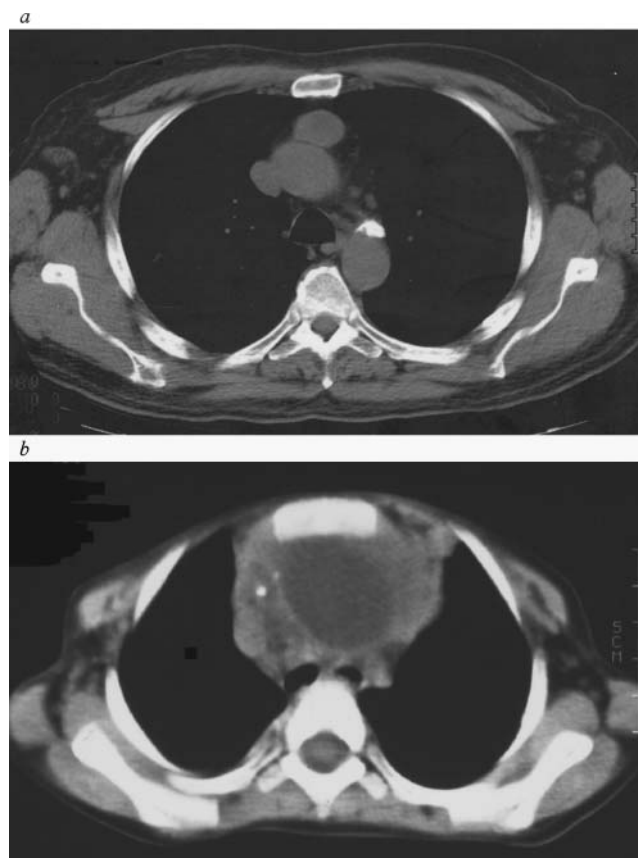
(a) Computed tomography (CT) scan shows a well-encapsulated anterior mediastinal mass—a thymoma. (b) CT scan shows a benign teratoma of the anterior mediastinum; calcification and varying tissue densities may be seen.
